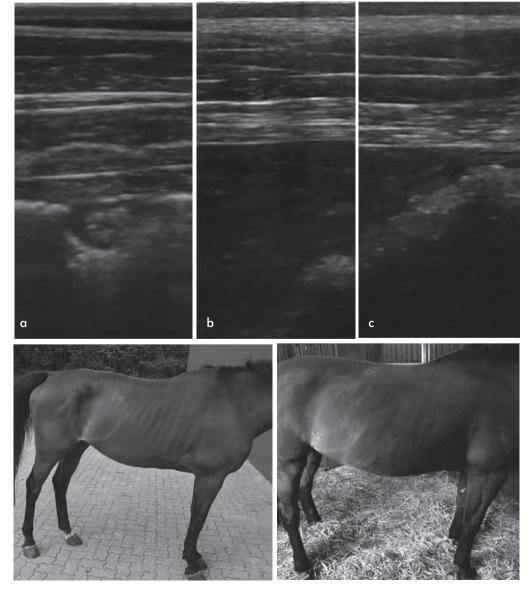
Case 3: Ultrasonographic finding at 7 weeks of treatment (13.9.21), 7a: smaller nodule, echogenic content, not well defined contour, 7b and c: consolidation of the lung still visible. | Fall 3: Ultraschallbilder sieben Wochen nach Therapiebeginn. 7a: kleineres Nodule, gefüllt, unscharf abgegrenzt. 7b und c: Konsolidierung der Lunge noch sichtbar
